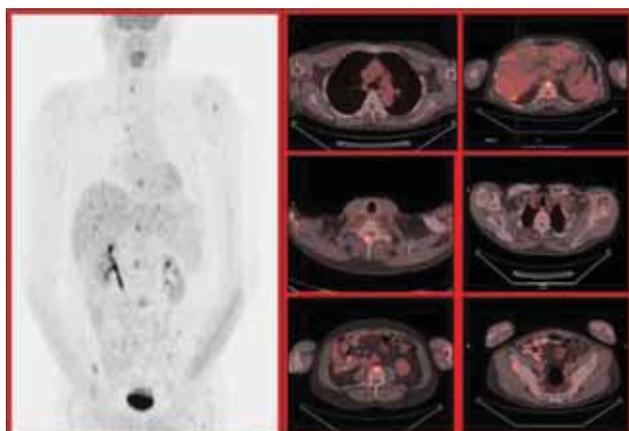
[^{18}F]FDG-PET and [^{18}F]FDG-PET/CT images in a 59-year-old man with known medullary thyroid cancer, as part of MEN IIA syndrome and calcitonin levels of 4800pg/ml, about 2 years after the initial treatment. Images show increased uptake of [^{18}F]FDG in multiple hepatic lesions (SUVmax: 6), a precarinal lymph node (SUVmax: 2.9) and in multiple bone lesions (SUVmax: 6.1).
